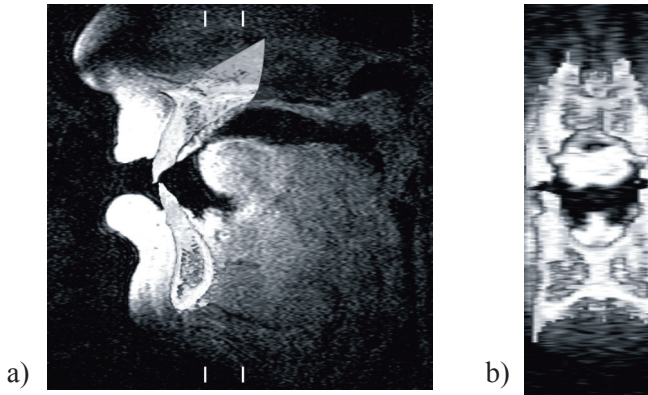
MRI-based (a) peroneal and (b) coronal cross-sections (taken from the place marked with lines in Figure 3a) of the prolonged articulation of the Polish consonant [ʂ] realised by speaker P2 in the imaginary context of the vowel [a].
